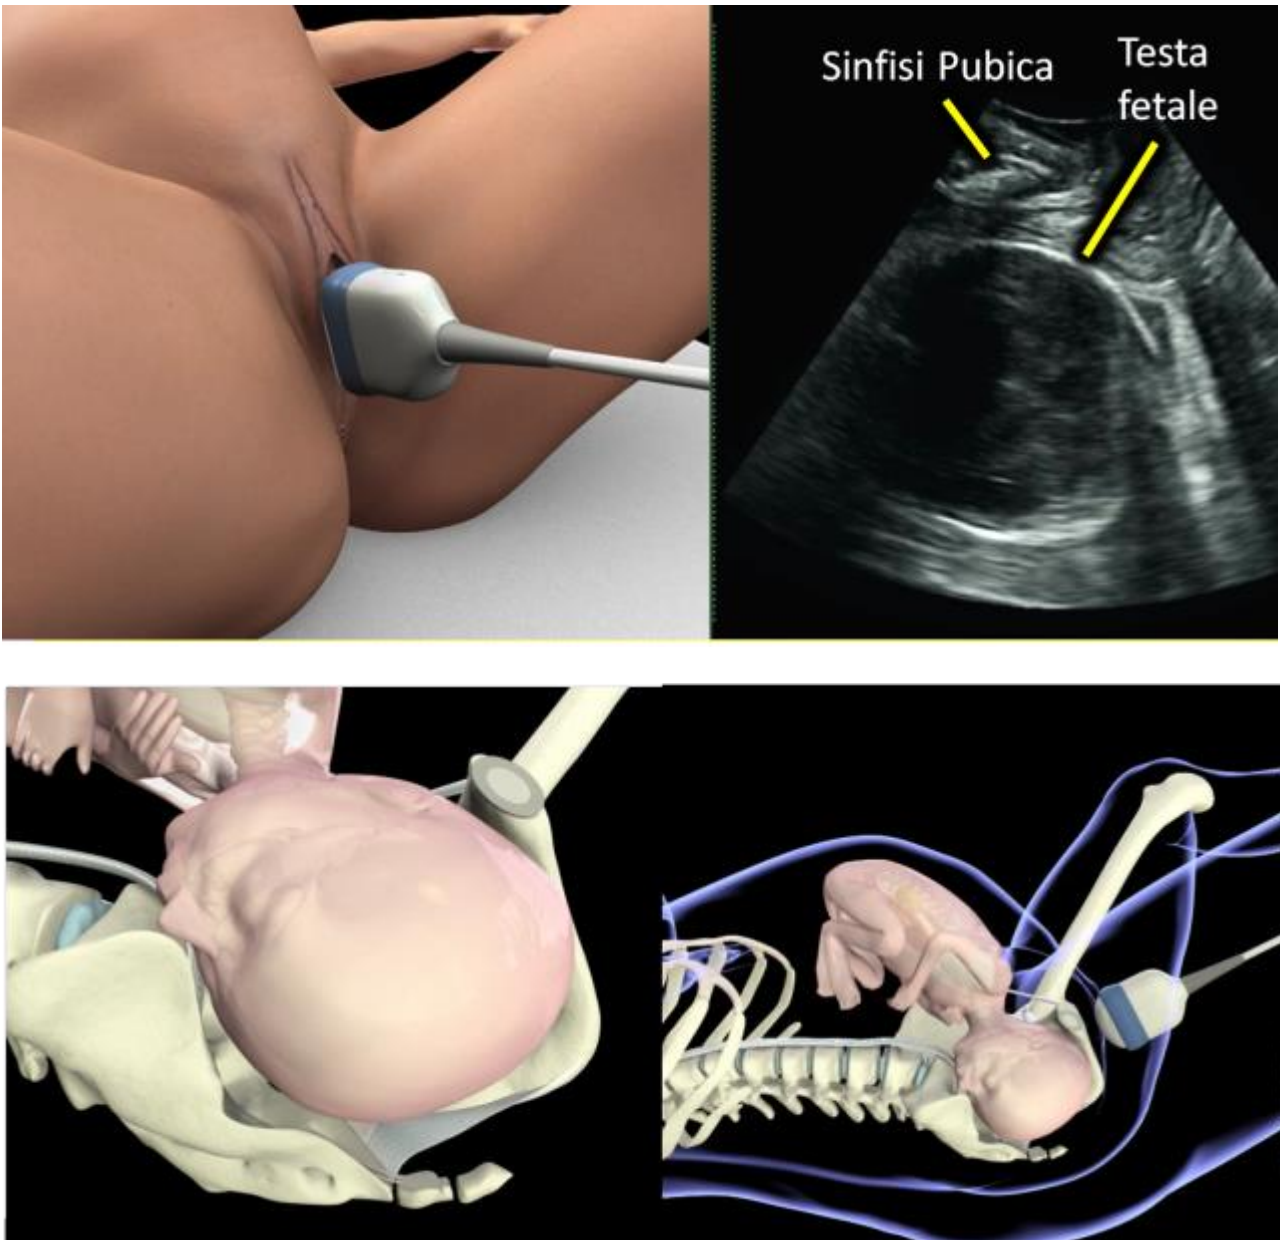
Representation of the transperineal ultrasound technique performed during labor.
